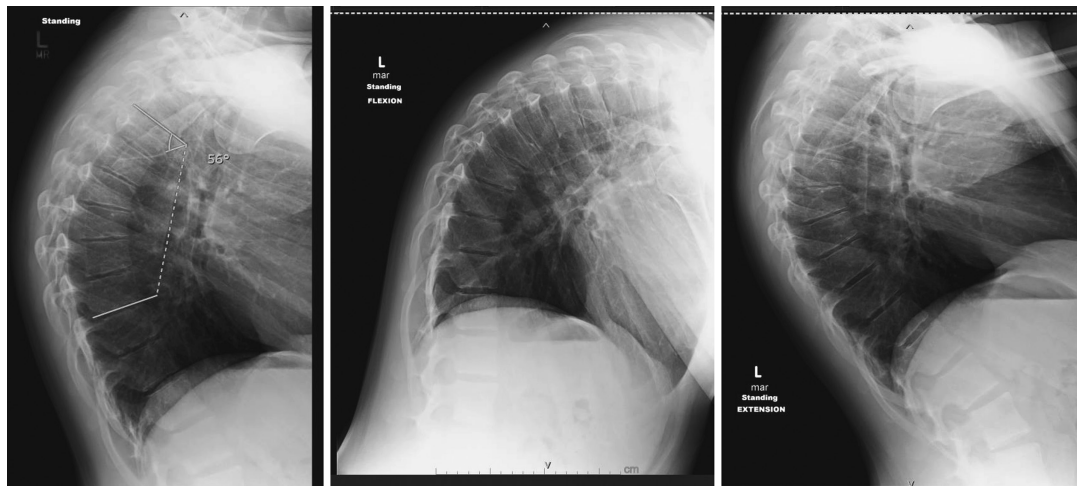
Lateral, flexion, and extension radiographs—Note the contiguous anterior wedging of thoracic vertebrae with a measured angle of 56° and no dynamic instability.
